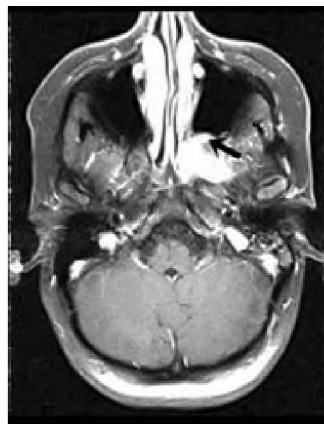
Preoperative magnetic resonance imaging showing a meningioma that originated from left sphenoid wing. This tumor recurred 4 years after initial resection and invaded into infratemporal and pterygopalatine fossae as well as maxillary sinus (indicated by arrow).
